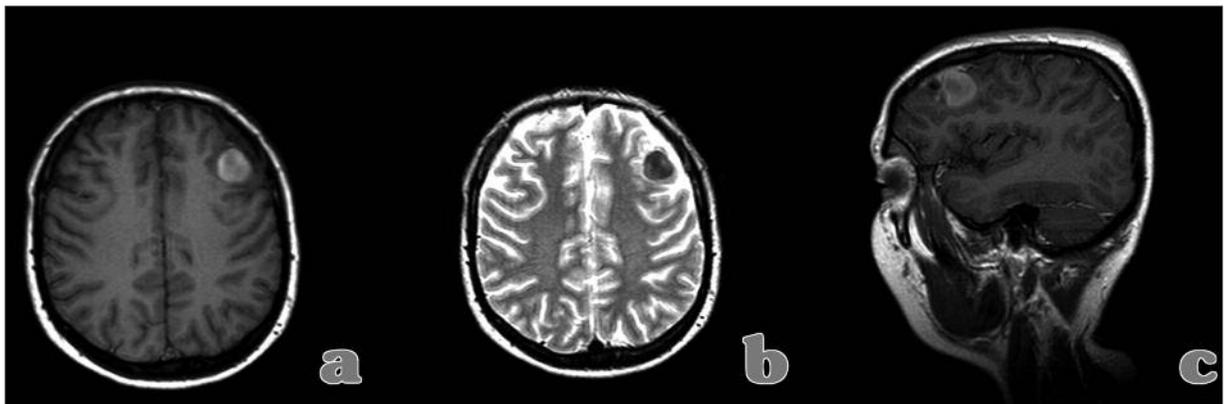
a) Axial T₁-weighted MR image showing the lesion with peripheral hyperintensity and central isointensity b) Axial T₂-weighted MR image showing the centrally hypointense lesion c) Sagittal T₁-weighted MR images with gadolinium showed no enhancement of the lesion.
